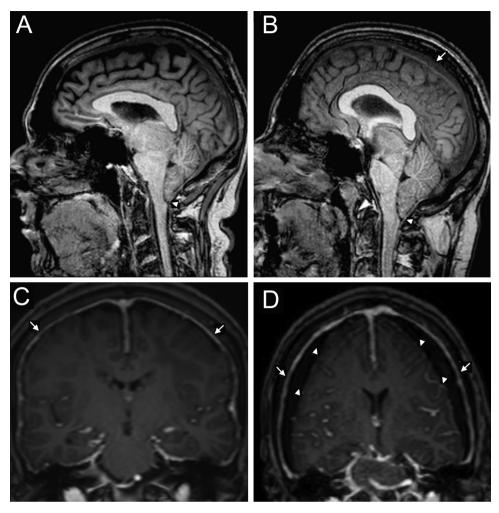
Magnetic resonance imaging (MRI) findings in patients with Chiari malformation (CM) and intracranial hypotension (IH). Sagittal 3D T1-weighted FFE sequence demonstrates descent of the brainstem and the cerebellum through the posterior cranial fossa and the occipital canal (white triangle) in a CM (A) and IH (B). To note the narrowing of the cisternal spaces, cerebellar tonsillar herniation and subdural effusions in IH (white arrow, B). Post-contrast axial T1-weighted images of two IH patients showing hyperintense leptomeningeal signal (white arrows, C—D) and bilateral subdural effusion (white triangles, D).
